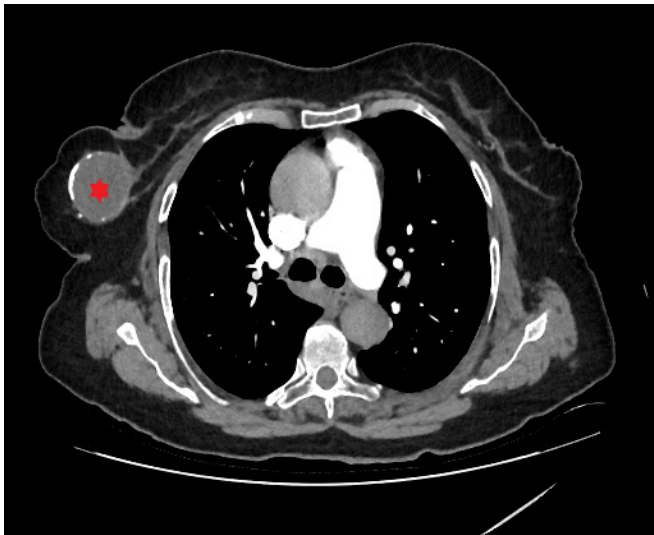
A well-circumscribed hypodense mass lesion with wall calcification located in the upper outer quadrant of the right breast, as observed on thoracic computed tomography (red star).
